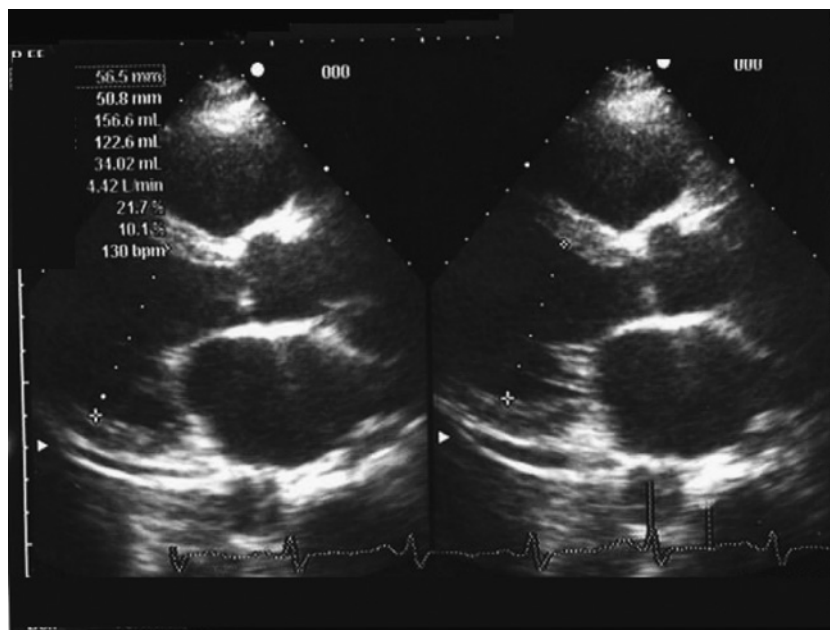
Echocardiography on the day of admission revealed severely decreased LV function with an estimated ejection fraction of 21.7%, LV dilatation (LV end-diastolic diameter, 58 mm; LV end-systolic diameter, 50 mm), and mitral valve regurgitation of grade II to III.
